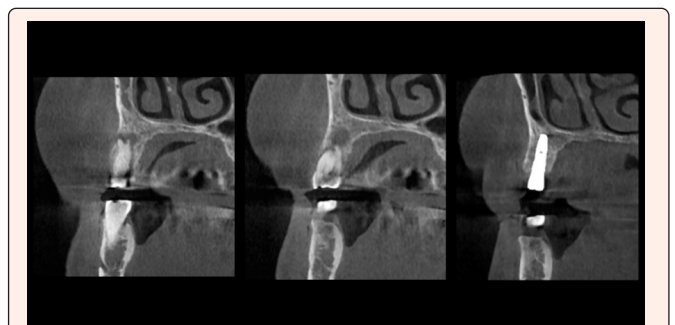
(a) CBCT before surgery (b) CBCT after surgery.
